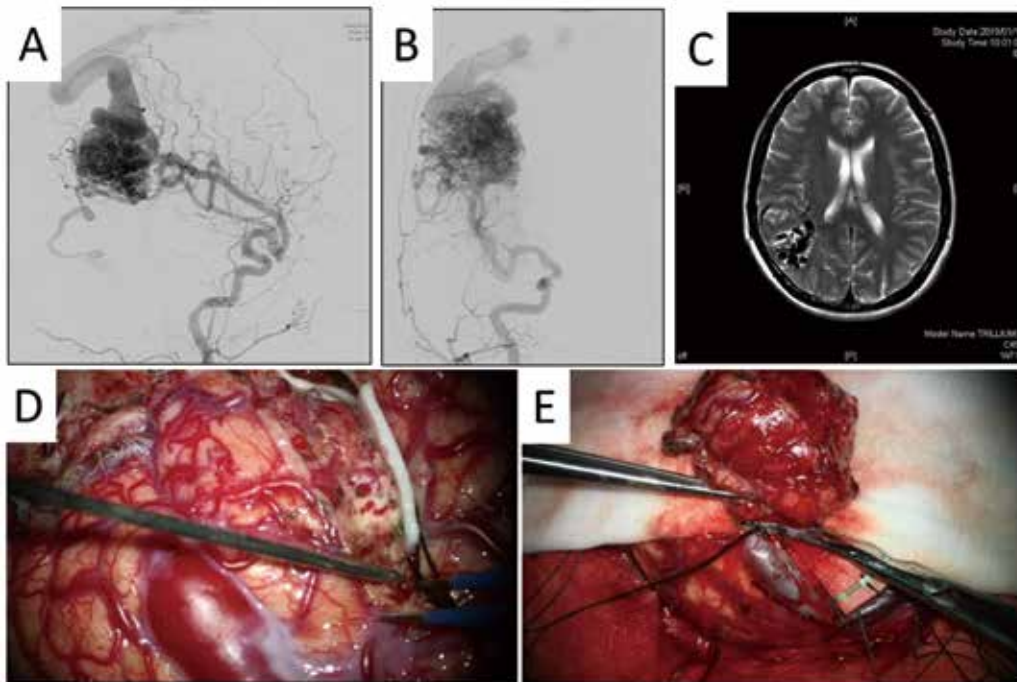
Case 1. A. Right internal cerebral angiogram (lateral view). B. Right internal cerebral angiogram (AP view). C. MRI T2 weighed image; AVM is located in the right frontal lobe. D and E. Intraoperative view.
